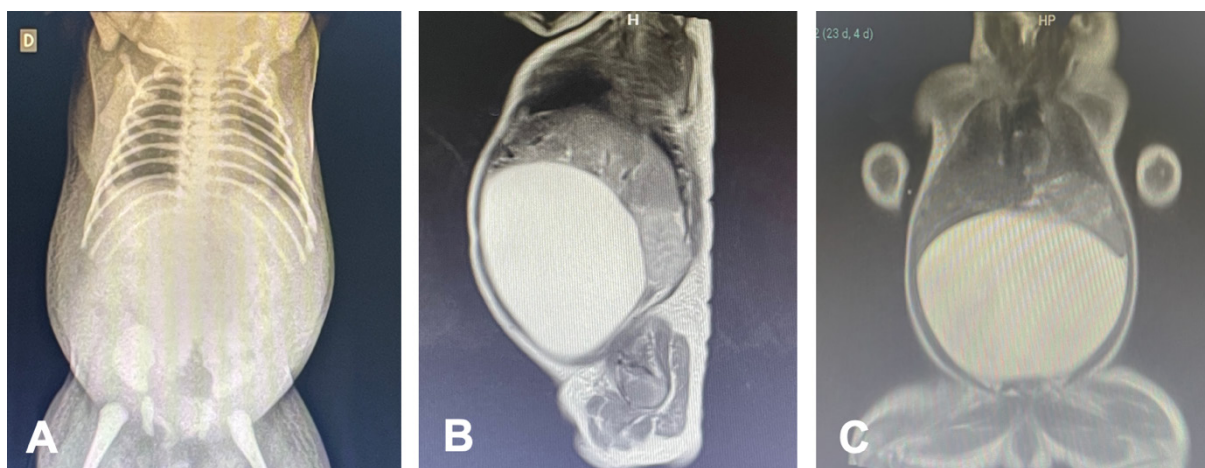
A – X-ray of the abdomen showing a globular abdomen, with distention of the intestinal loops to the left; B – sagittal section magnetic resonance imaging with a large cystic lesion in the peritoneal cavity; C- Coronal magnetic resonance imaging, showing a large cystic lesion.
